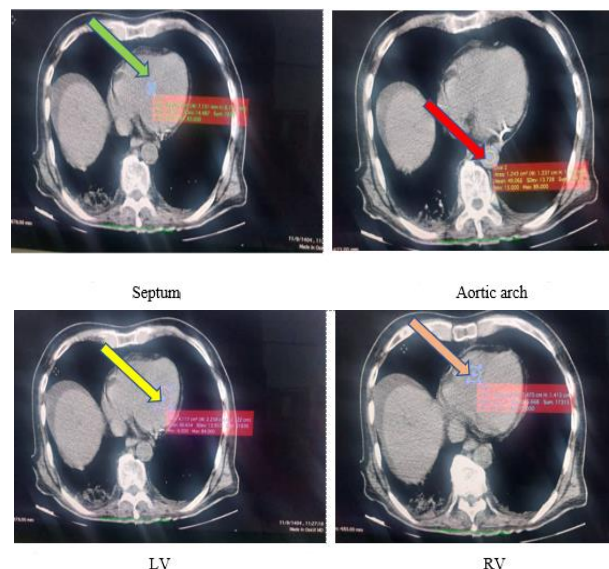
Representative non-contrast axial cardiac CT images demonstrating the regions of interest (ROIs) used for attenuation measurements in the left ventricle (LV), right ventricle (RV), interventricular septum, and aortic arch.
